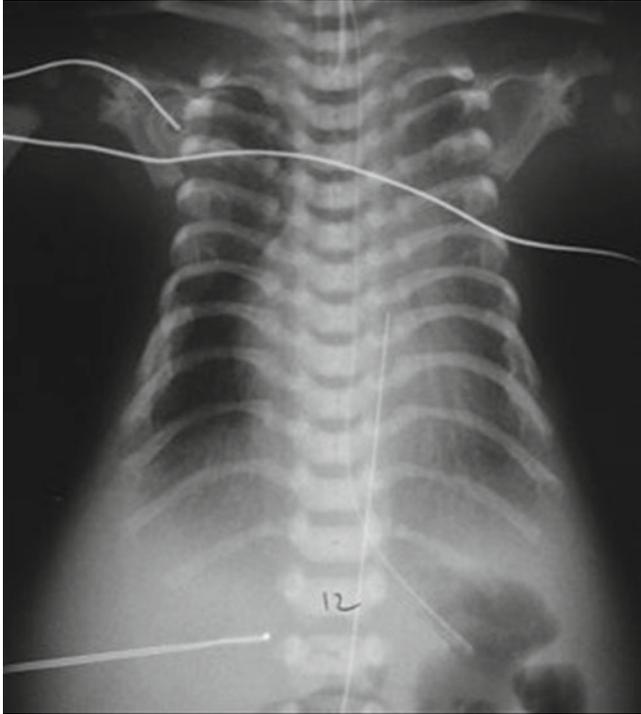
Chest wall deformity. Chest radiograph of a patient with Jeune syndrome. Small chest with short, horizontally oriented ribs and irregular anterior ends. Note the NG tube tip in the stomach, an UAC with tip at the level of T6 vertebral body and an ETT tip at the level of the cervicothoracic junction
